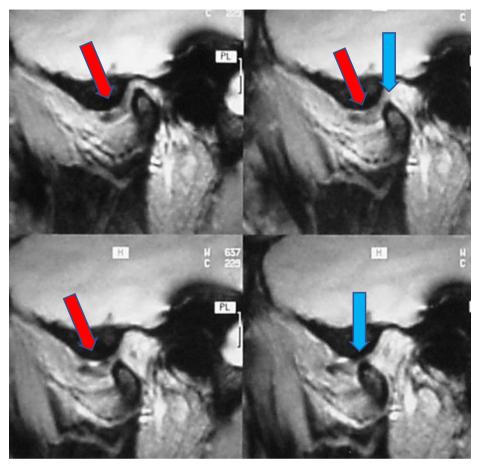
(A-D): Dynamic Magnetic Resonance Imaging: irreducible dislocation of the articular meniscus during the condyle excursion manoeuvre (red arrows), with initial arthritic degeneration of the apex of the condyle (blue arrows)
